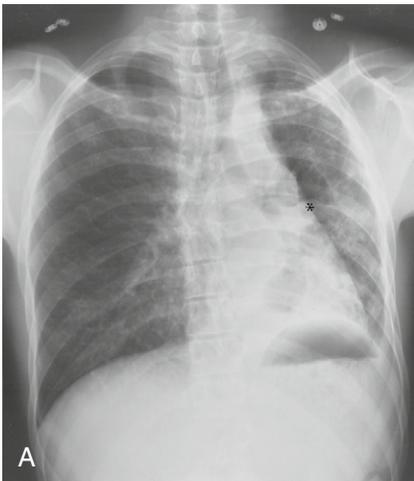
Aspergilloma in a 24-year-old man with previous tuberculosis, a 2-day history of productive blood-tinged sputum, and a weight loss of 17 pounds. (A) Upright PA chest radiograph shows extensive volume loss and marked bronchiectasis in the left lung with surrounding consolidation and small nodular opacities. A rounded mass (*asterisk*) is present in the dependent portion of one of the bronchiectatic areas. The air crescent surrounding the mass is quite large. Fluid obscures the dependent portion of the mass. Both features make the correct diagnosis, aspergilloma, difficult. (B) Contrast-enhanced chest CT image (soft tissue window) with the patient in the supine position shows that the mass (*asterisk*) has moved to the dependent portion of the "cystic" lesion. Note the wide air crescent and the small amount of fluid adjacent to the dependent portion of the mass. Left pneumonectomy confirmed an aspergilloma and extensive bronchiectasis.
